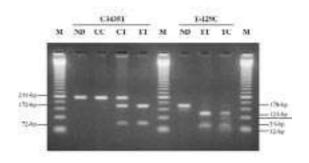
Agarose gel electrophoresis following *Dpn*II restriction digestion of a 244-bp DNA fragment of exon 26 of *MDR1* gene (A) and following *Msp*A11 restriction digestion of a 178-bp DNA fragment of exon 1 of *MDR1* gene (B). Lane 1, molecular weight marker (M); lane 2, exon 26 fragment not digested (ND); lane 3, wild-type 3435C genotype (CC); lane 4, CT, heterozygosity for C3435T; CT, heterozygosity for C3435T (CT); lane 5, homozygosity for C3435T (TT); lane 6, molecular marker; (m), lane 7, exon 1 fragment not digested (ND); lane 8, wild-type -129T genotype (TT); lane 9, heterozygosity for T-129C (TC); lane 10, molecular marker (M).
